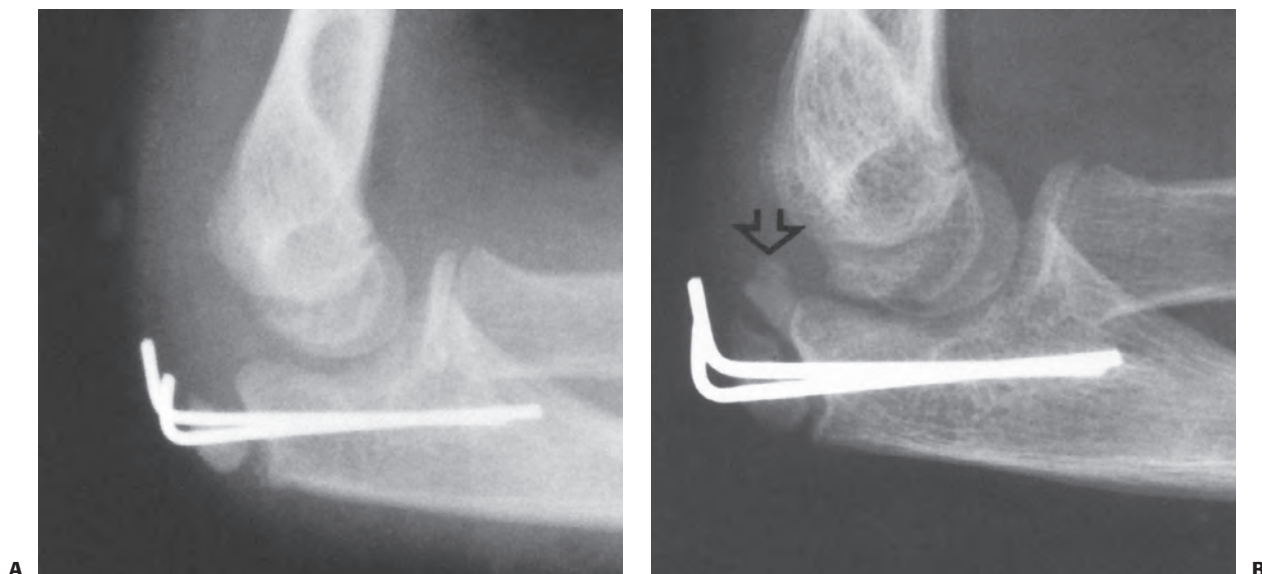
Operative treatment of an apophyseal fracture. A: Postoperative radiograph of the fracture shown in Figure 11-40D, which was stabilized with small Steinmann pins alone. B: Five months later, growth has continued in the traction center and the articular center is ossified (arrow).
